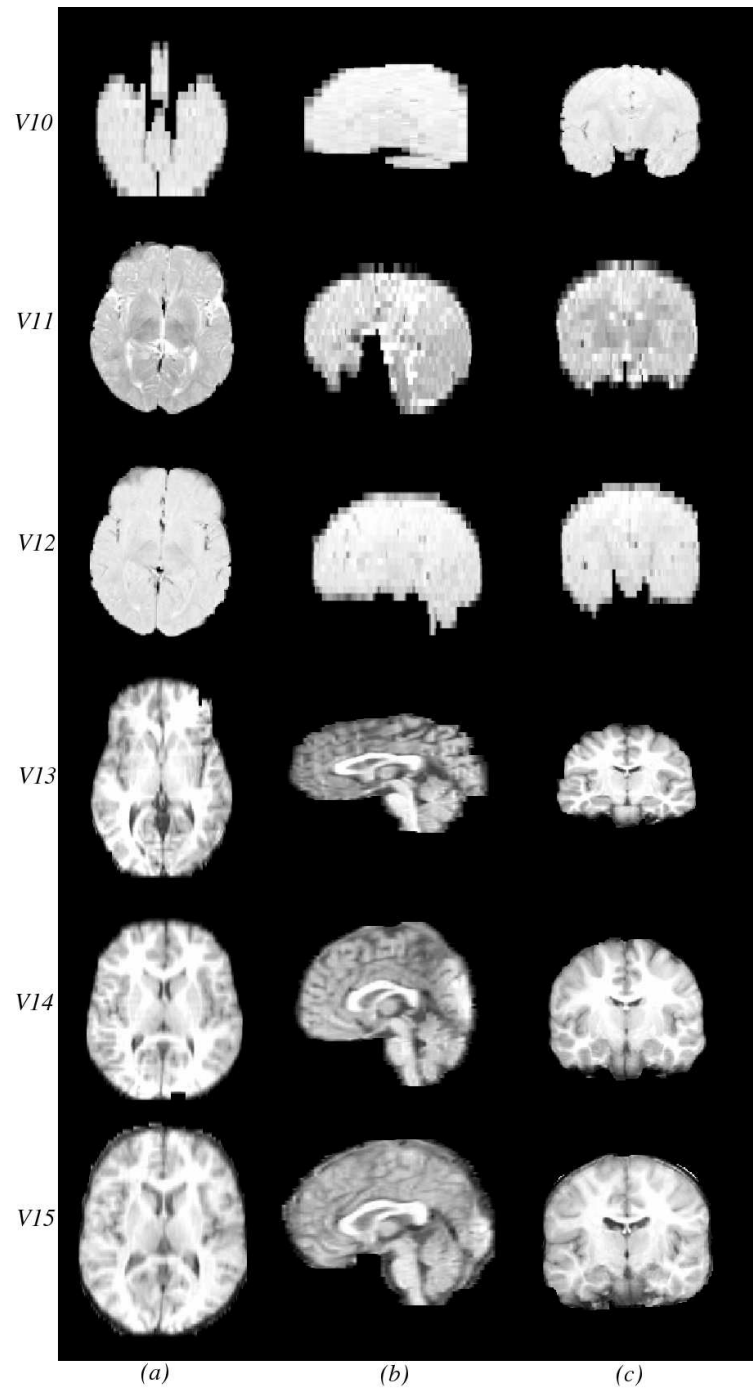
(a) Mid-transverse, (b) mid-sagittal and (c) mid-coronal image slices taken from the results of SMSS for evaluation test data sets V10 to V15. Each row represents a different data set, starting from V10 for row one and finishing with V15 for the final row (see table 3.1 for further details). Data sets V10 to V12 correspond to MRI scans of an infant.
